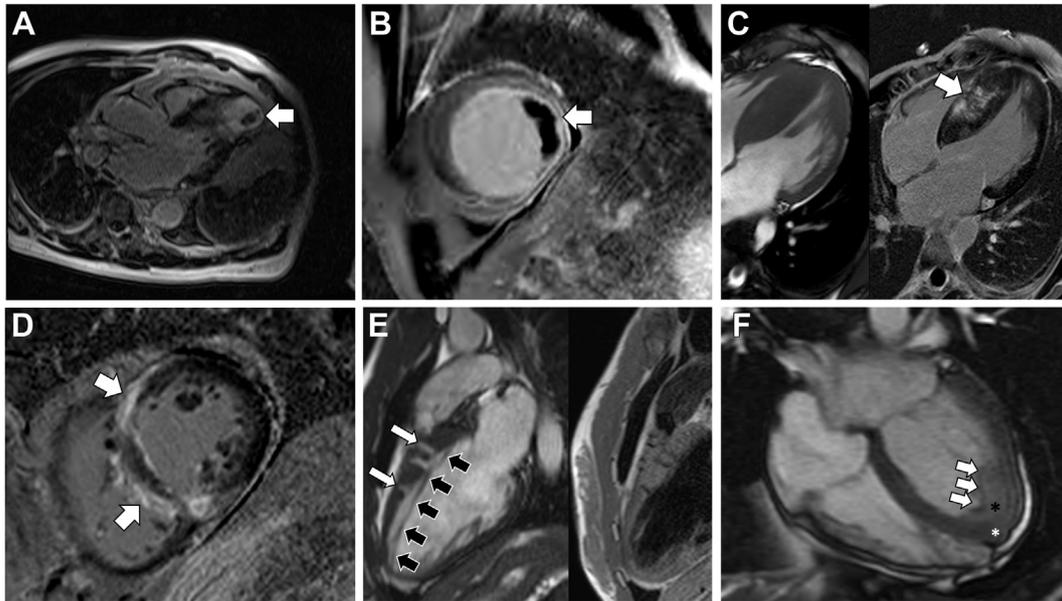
Additional hypertrophic cardiomyopathy (HCM) findings that might be identified using cardiac magnetic resonance. (A, B) Examples of apical aneurysm containing thrombus (arrow). Neither of these thrombi were identified initially using echocardiogram. (C, D) Examples in 2 different patients of severe fibrosis with late gadolinium enhancement imaging (arrows); a risk factor for major adverse cardiac events, including heart failure and sudden cardiac death. (E) Subtle findings in mild HCM might include myocardial crypts (white arrows), as well as a prominent apicobasal muscle bundle (black arrows). (F) Example of an apical HCM phenocopy—this is endomyocardial fibrosis; note the 3-layer appearance with myocardium (white asterisk), inflammatory infiltrate (black asterisk), and a thin rim of thrombus (arrows). Cardiac magnetic resonance imaging has sensitivity for differentiating endomyocardial fibrosis from apical HCM.
